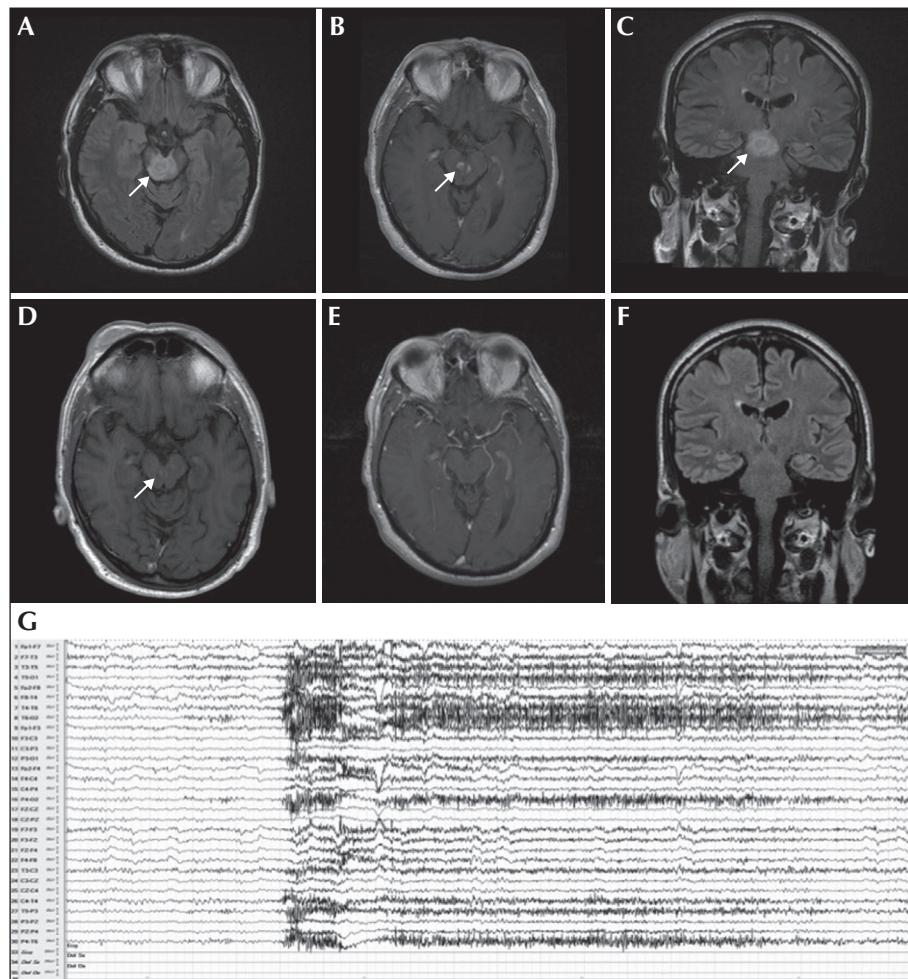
(A-C) Axial and coronal brain MRI showing enhanced right midbrain and a cystic lesion below the level of the red nucleus, extending to the midbrain-pons junction. After five months, MRI showed only a small level of nuanced midbrain flair hyperintensity (D-F) without enhancement (E). Ictal EEG, during hyperventilation, showed movement artefacts and myogenic potentials without paroxysmal discharges (G).
